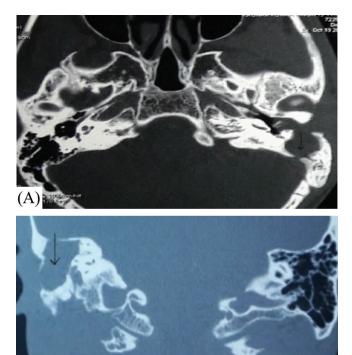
High Resolution CT temporal bone. (A) Axial section showing abnormal soft tissue density involving left mastoid antrum and middle ear cavity with erosion of sigmoid plate and lateral mastoid cortex. (B) Coronal section showing abnormal soft tissue density in right mastoid air cells with erosion of tegmen plate and lateral mastoid cortex with widening of mastoid antrum.
